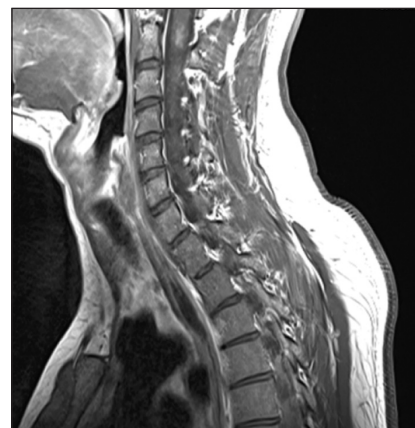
Spinal cord MRI, T1 weighted image: contrast uptake was detected at the level of C₁₁
